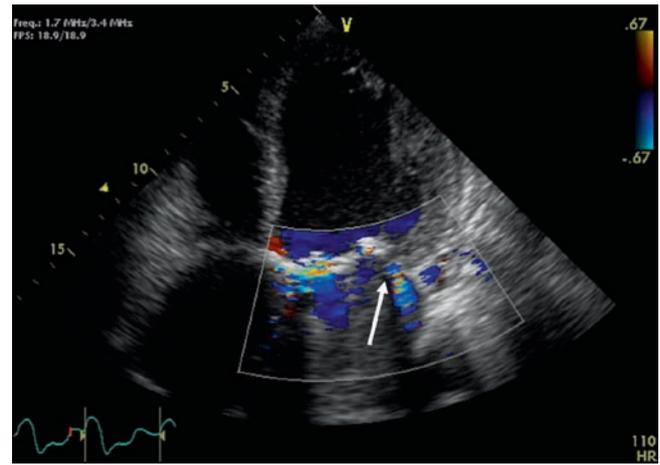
Prosthetic mitral regurgitation jet (*white arrow*) detected by transthoracic echocardiography despite shadowing artefacts in the left atrium caused by the mechanical prosthesis
